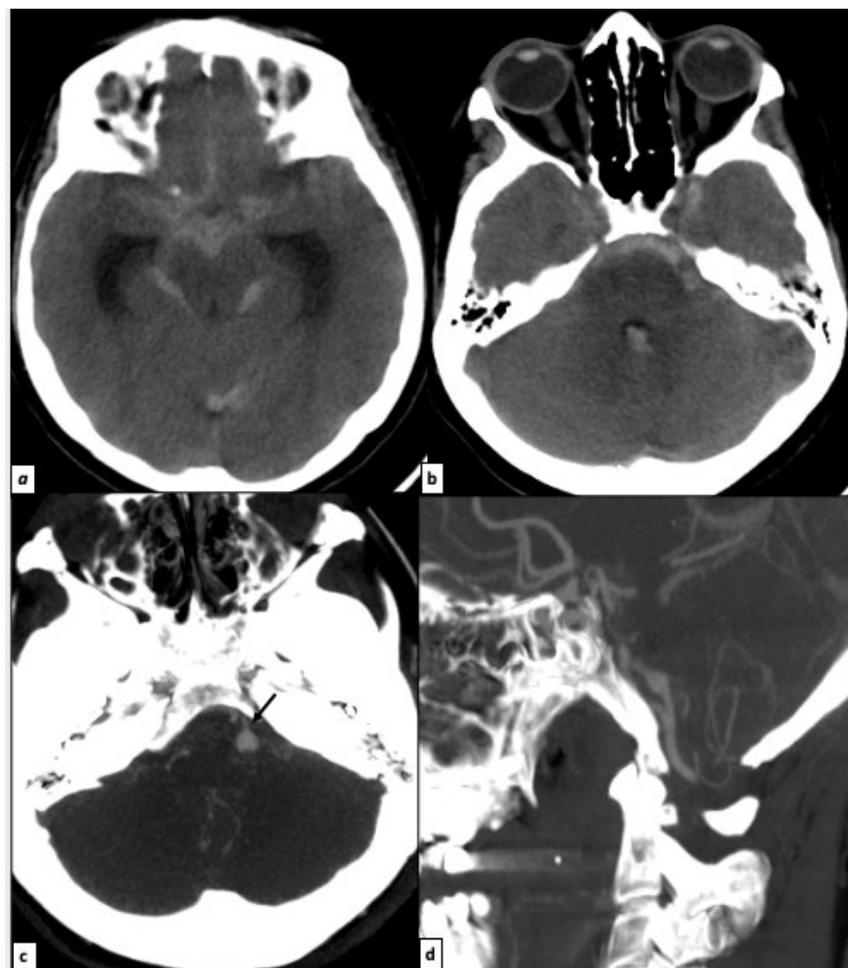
45 years old patient. (a): Non enhanced brain CT: spontaneous subarachnoid hemorrhage. (b, c): Brain angiography showing a succession of stenoses and tubular dilations of the V4 segment of the right vertebral artery.
